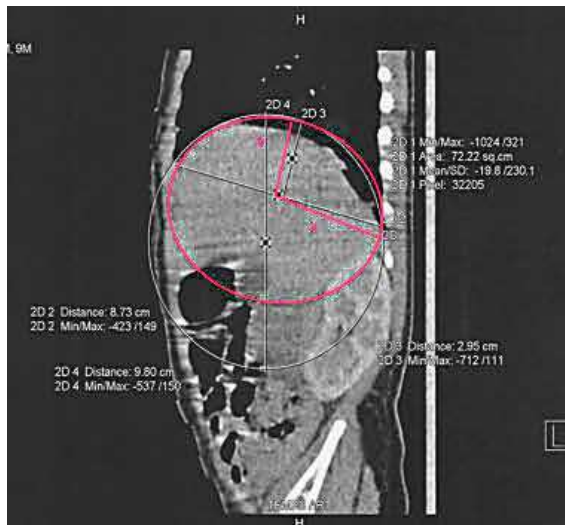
Method 2: Diaphragmatic surface calculation. Sagittal view of the ellipsoid following the diaphragmatic dome on a CT scan with a = half major axis of the ellipsoid and b = half minor axis of the ellipsoid.
